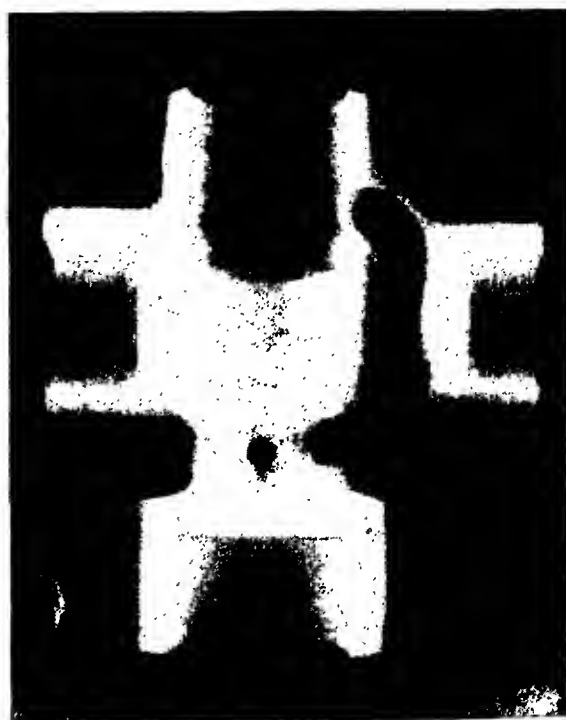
Radiograph of a machined bronze valve casting. Distance, source to film, $27\frac{1}{2}$ inches; exposure, 1,600 milligram-hours; two lead screens; one film.
